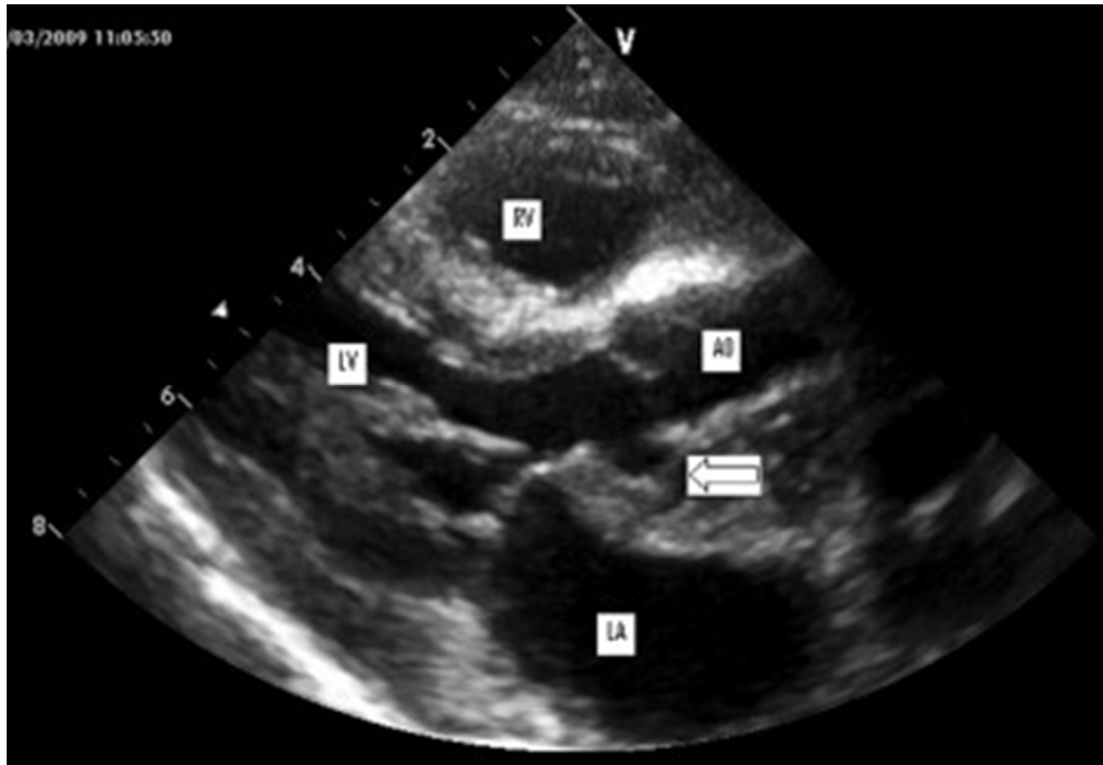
Repeat transthoracic echocardiogram 6 weeks after presentation. Parasternal long axis view demonstrating a small pouch in the subaortic area (arrow). (AO = aorta; LA = left atrium; LV = left ventricle; RV = right ventricle.)
